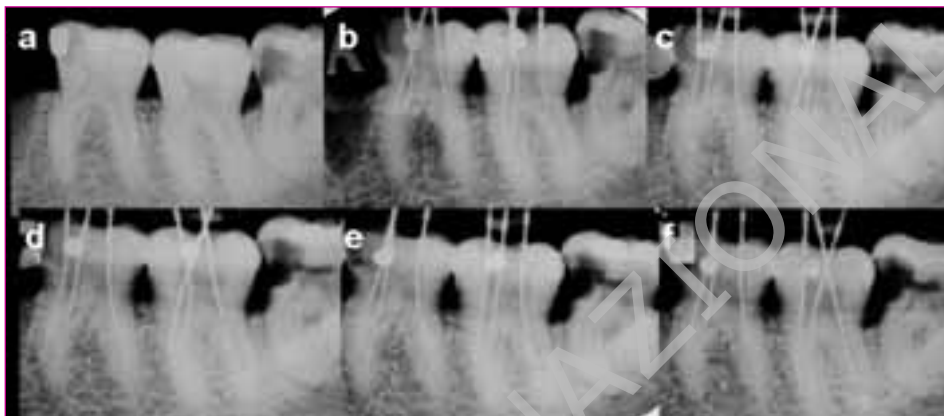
Sequence of periapical radiographs taken with Agfa Dentus M2 Comfort films.
